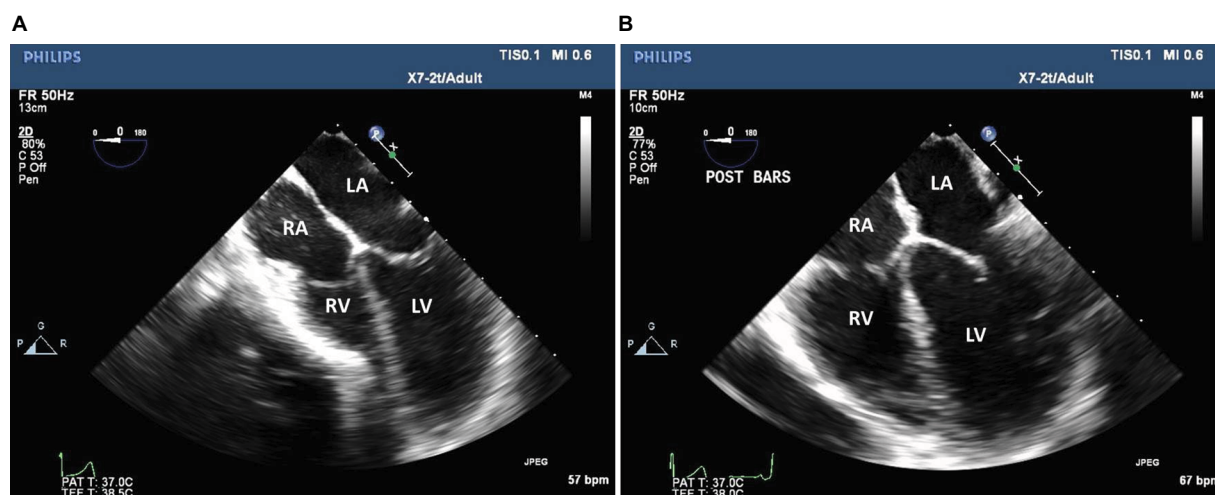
Transesophageal echocardiographic images show preoperative effect (A) of pectus excavatum with compression on the right ventricle due to the inward sternal deformity and relief of the compression following surgical repair (B).
